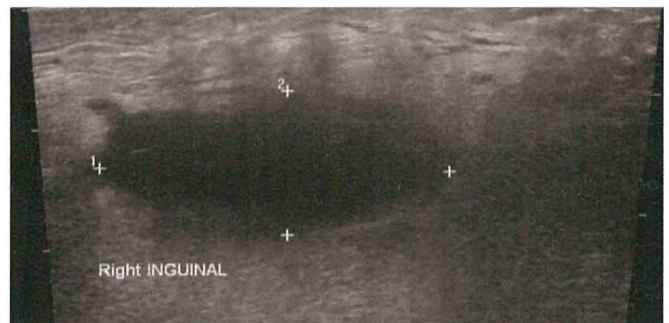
Ultrasound scan showing a fluid collection (calipers) at the site of a hernia repair in the early post-operative period.
